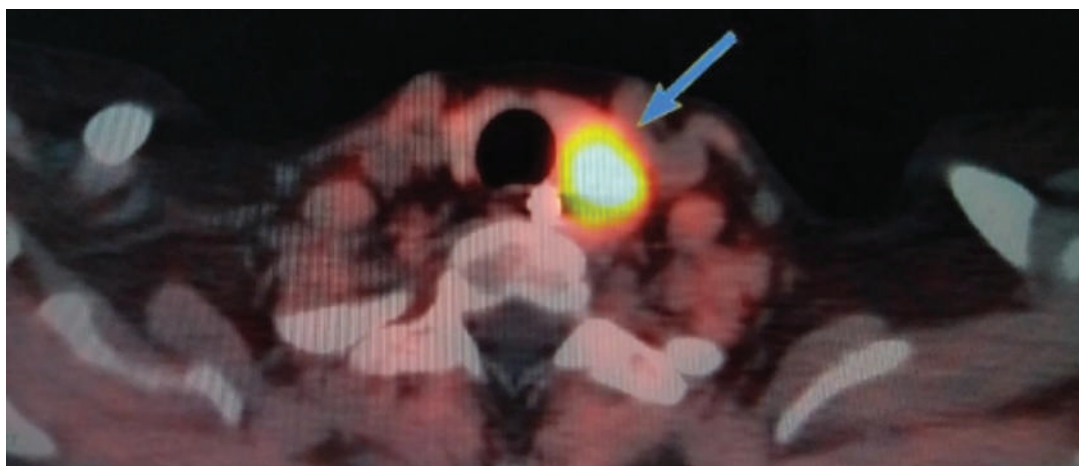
¹⁸F-Fluorocholine PET/CT scan showing transaxial image of intense tracer uptake behind left lobe of thyroid suggesting parathyroid hyperactivity (arrow).
